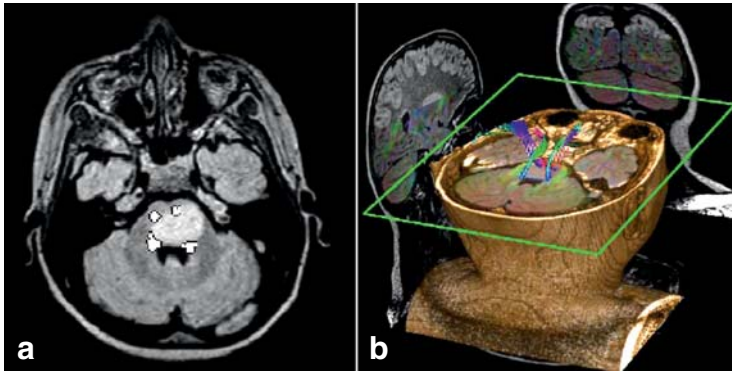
Magnetic resonance images of a pontine glioma with anatomical fiber tracking. Figure 2 a) (axial) shows color-coded fiber pathways; the craniocaudal fibers on the left side are clearly displaced and spread apart. Figure 2 b) shows the same finding in a three-dimensionally reconstructed color image.
